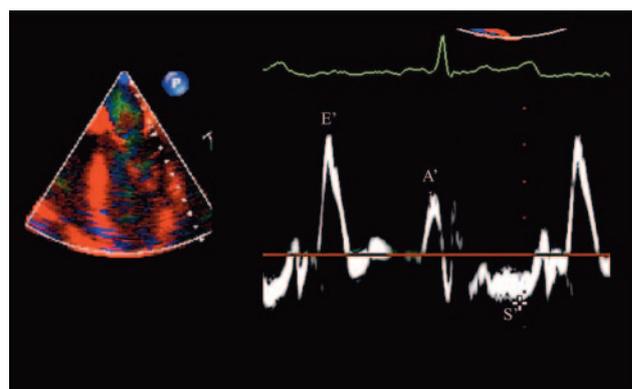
Spectral tissue Doppler display. E' = rapid relaxation wave; A' = atrial systolic wave; S' = ventricular systolic wave.
